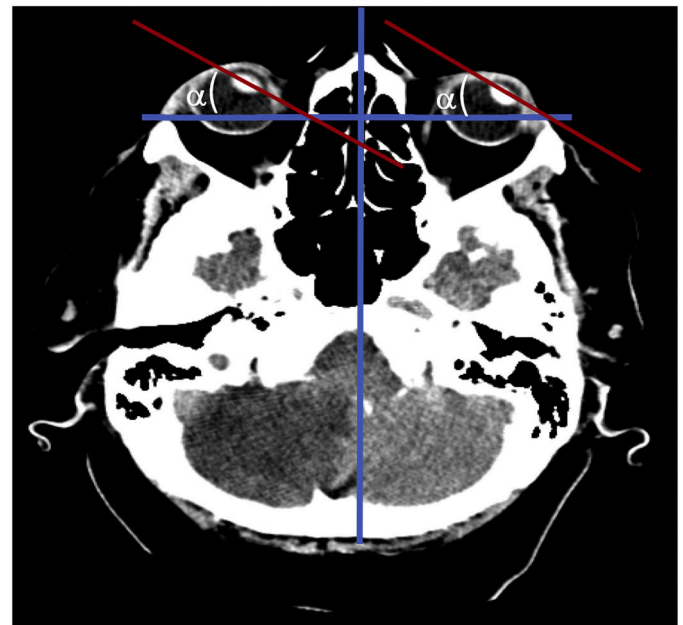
Measuring gaze deviation (α) on non-contrast CT scan of the head in a stroke code patient presenting to the emergency department.
